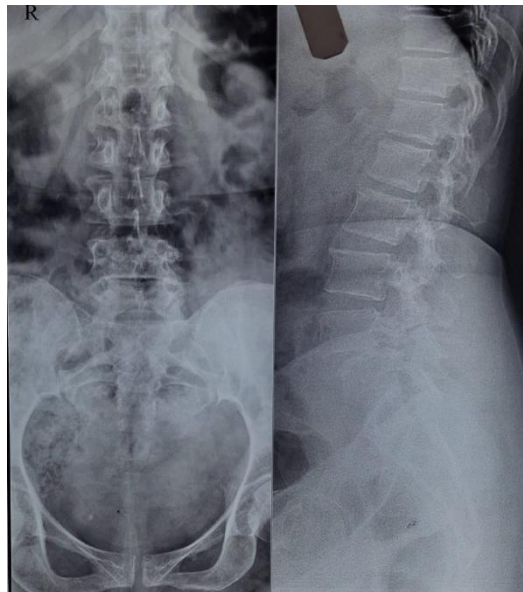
Preoperative X-ray - AP & Lateral view
